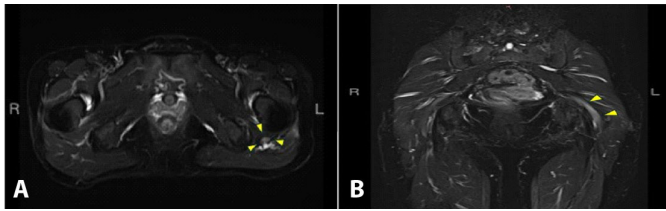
(A) An axial section of short T inversion recovery (STIR) in pelvic MRI. (B) A coronal section of STIR in pelvic MRI showing elevated STIR signals and enlargement (arrowhead) in the left sciatic nerve at the level of the femoral head-trochanteric region, suggesting the presence of inflammation or ischemia.
